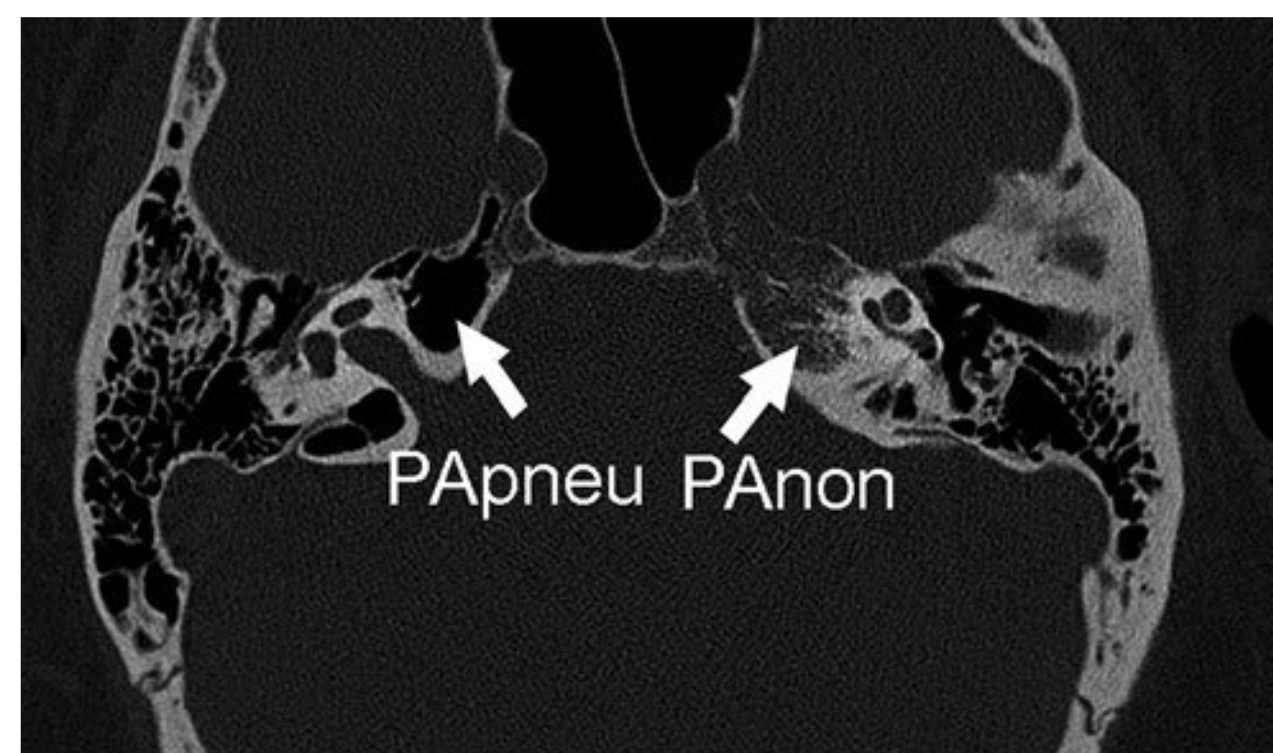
Axial computed tomography image through the petrous apex demonstrates the variability in pneumatization of the petrous apex. The petrous apex on the right is well pneumatized and demonstrates air density (PApneu); the contralateral petrous apex is nonpneumatized and demonstrates bone trabecular bone density (PAnon).
